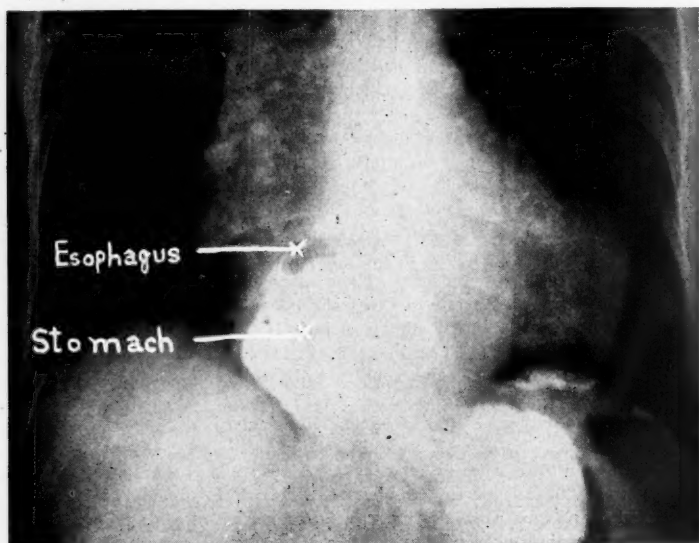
Radiograph taken on March 20, 1947.
